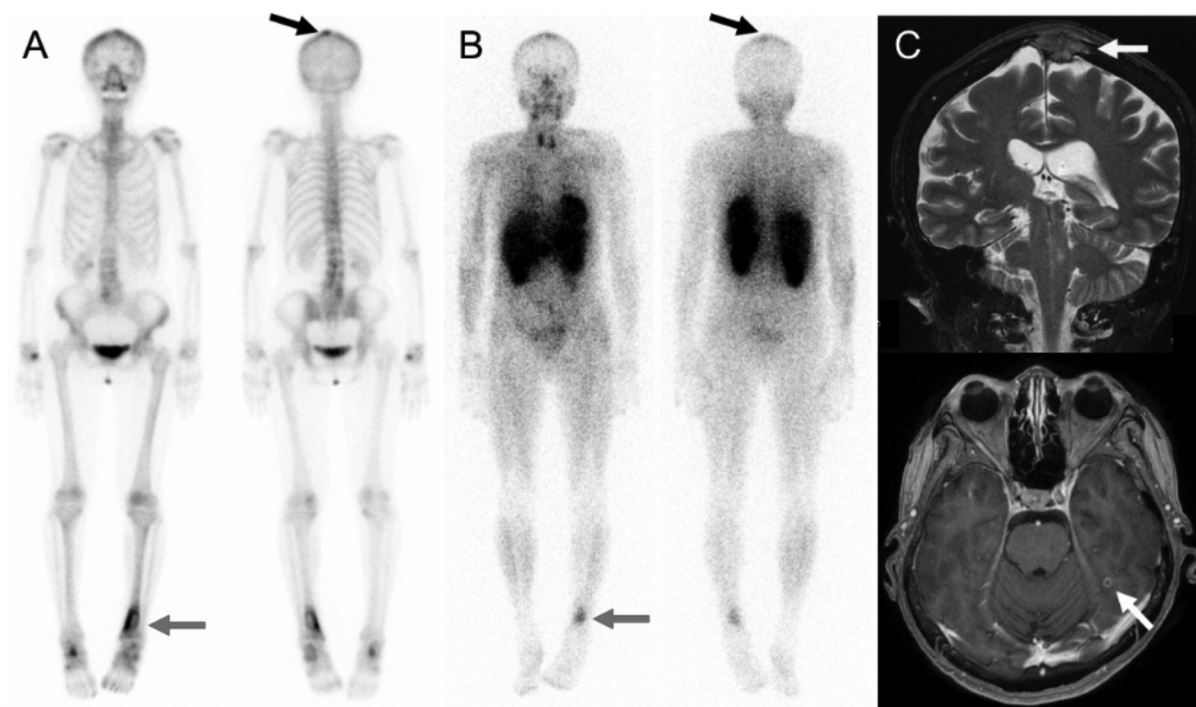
Case 2: A 71-year-old man who had no past medical history complained of right thigh pain. Initial bone (A) and thallium (B) scans showed abnormal accumulation in the skull (black arrow) and left distal tibia (red arrow). Magnetic resonance imaging revealed metastatic lesions of the brain (white arrow) and skull (yellow arrow) (C).
